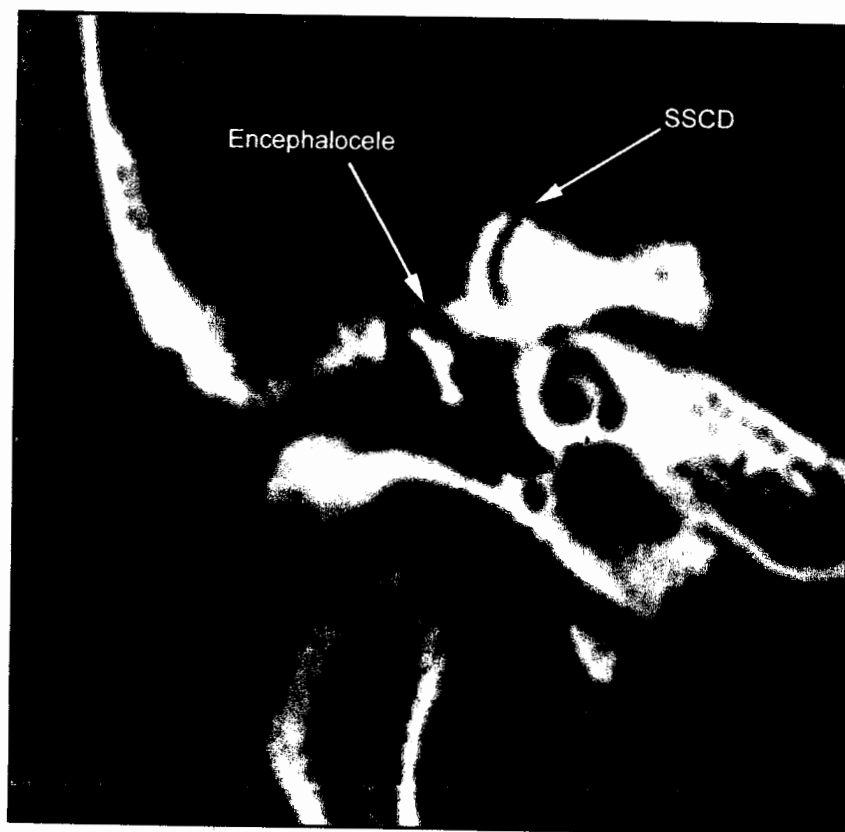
Coronal CT scan in a case of an encephalocele with concomitant SSCD.
